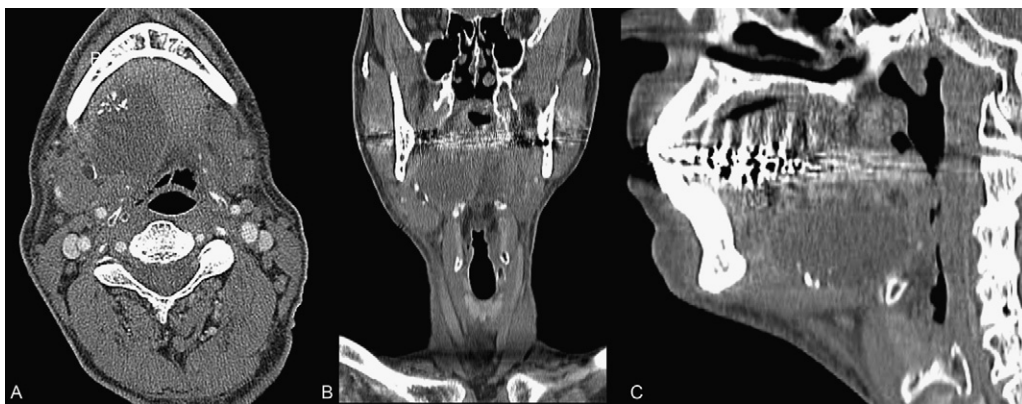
Contrast-enhanced CT imaging in axial, (A) coronal, (B) sagittal, (C) soft tissue windows demonstrated a 4.4 cm × 3.0 cm × 3.5 cm mass containing heterogeneous calcifications and rounded fat attenuation.
